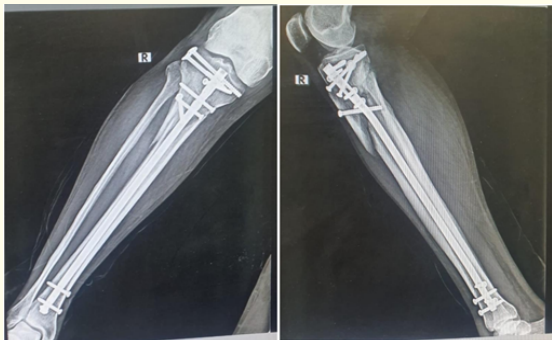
Immediate post op X-rays.
